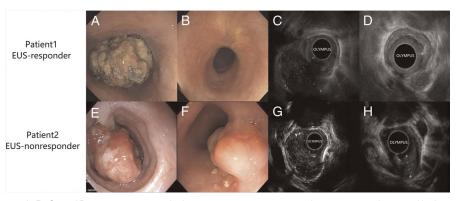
EUS measurement. A, B, C, and D were gastroscopy before treatment, gastroscopy after treatment, ultrasound before treatment, and ultrasound after treatment for patient 1, respectively; E, F, G, and H were gastroscopy before treatment, gastroscopy after treatment, ultrasound before treatment, and ultrasound after treatment for patient 2, respectively. EUS responder, tumor shrinkage rate \geq 52%; EUS nonresponder, tumor shrinkage <52%.
